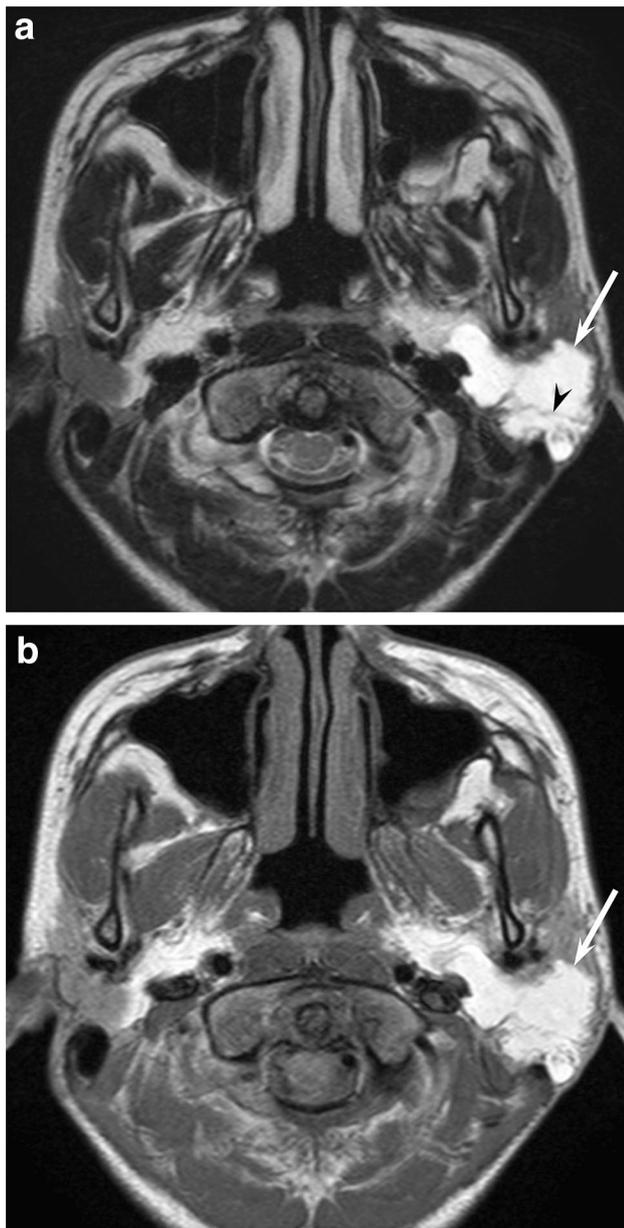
A 12-year-old girl with lymphatic malformation. a T2-weighted image shows a lobulated cystic lesion (arrow) with internal septum (arrow head) in the left parotid gland. b T1-weighted image shows a hyperintense cystic lesion (arrow) due to hemorrhage
